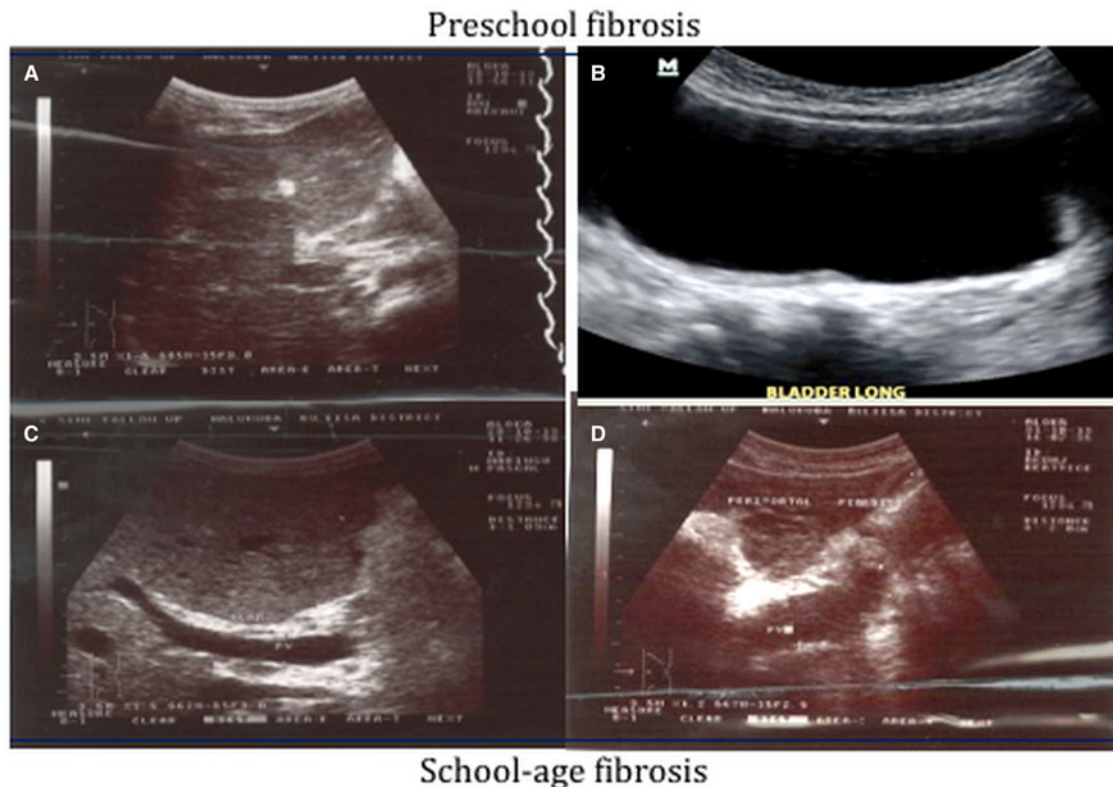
Ultrasound findings by WHO classification. Preschool children in (A): Uganda – Liver fibrosis-stage C on a 4-year-old girl and (B): Gabon – early bladder polyp and bladder thickening in a 2-year-old boy. School-aged children (C): Uganda – 12-year-old boy with stage D fibrosis (D): 16-year-old girl with stage E fibrosis. N.B. Image B – courtesy of Dr. Jonathan Remppis.
